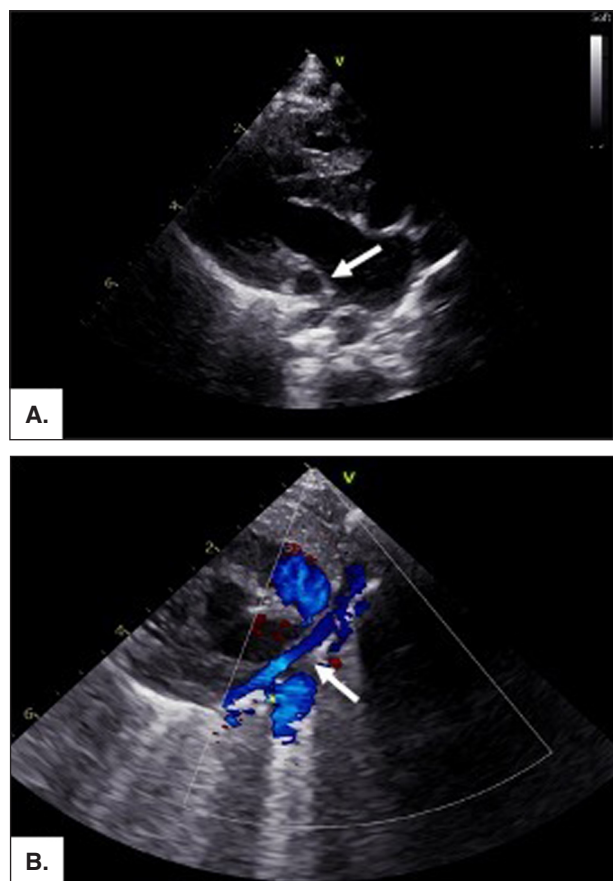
Echocardiographic image of the persistence of the left superior vena cava (PLSVC). A. Parasternal long-axis view showing classic dilatation of the coronary sinus (white arrow). B. Modified parasternal short-axis view showing PLSVC, which drains into the coronary sinus (white arrow).
